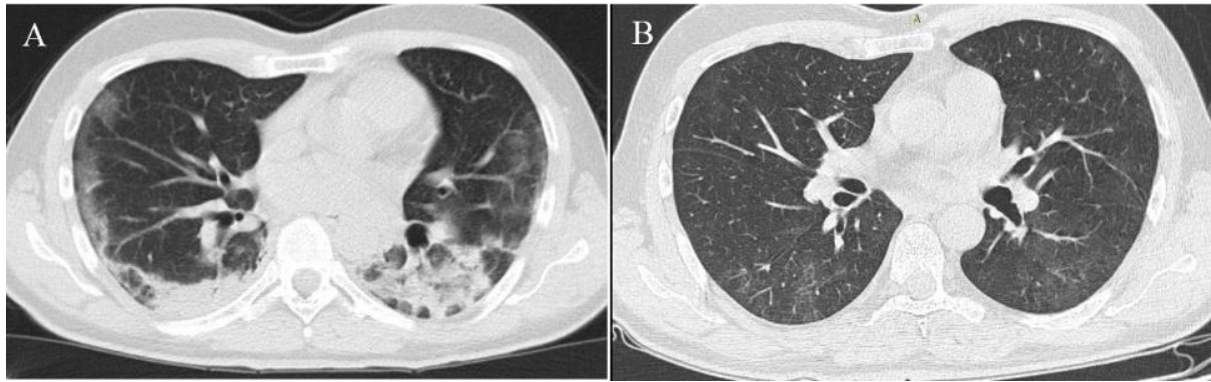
A: Initial chest CT scan of a 69-year-old patient admitted to ICU, which shows bilateral ground glass opacities. (The TLI score was 10.) B: Follow-up CT of the same patient shows atelectasis and fibrotic bands.
